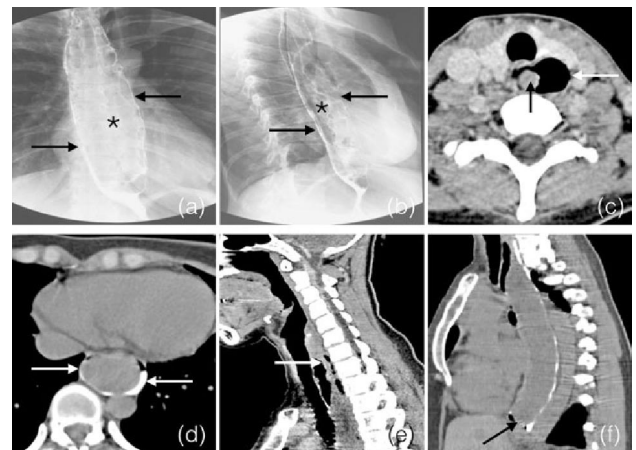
Barium swallow images (a) and (b) showed dilated oesophagus (arrow) with intraluminal mass (*) with filling defect. Transverse CT scan images (c) and (d) showed the stalk of the mass (black arrow) in dilated oesophagus (white arrow). Reformatted sagittal CT images clearly showed the stalk (white arrow) in (e) and inferior margin of the mass (black arrow) in (f).
